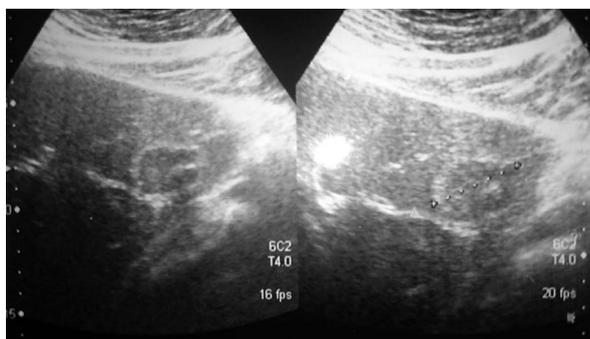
Control ultrasonography: Persistent focal oval heteroechoic lesion in the left hepatic lobe
